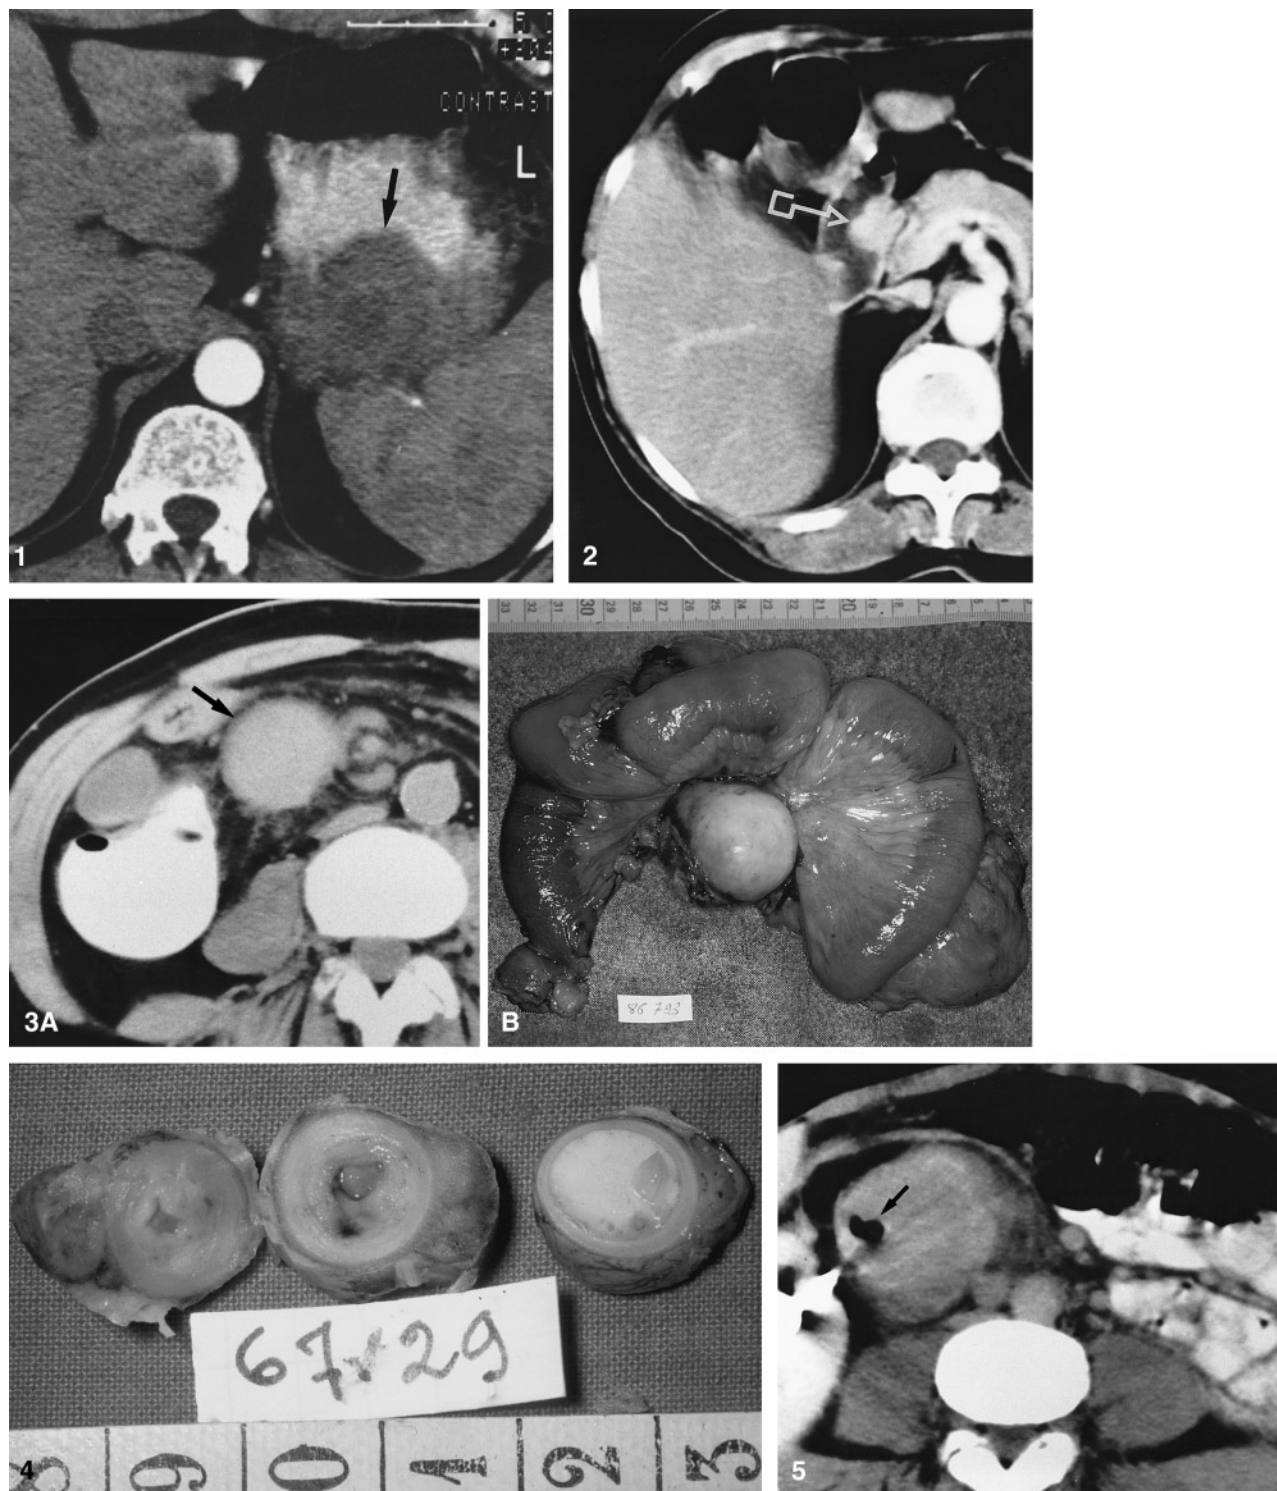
A 50-year-old man with carcinoid tumor of the stomach. CT shows nonspecific parietal mass (*arrow*) arising from the gastric wall.
